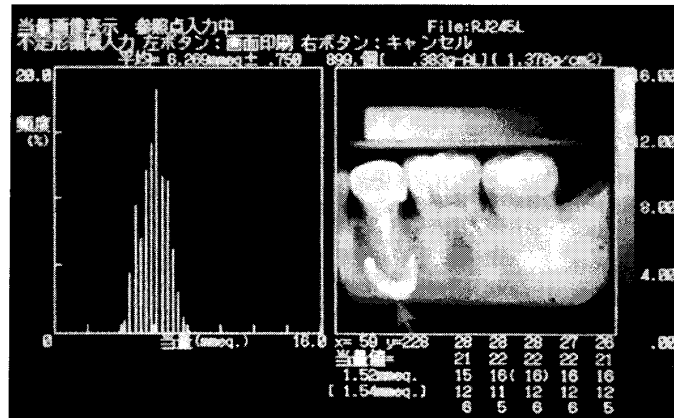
Periapical Bone Changes after root canal treatment
